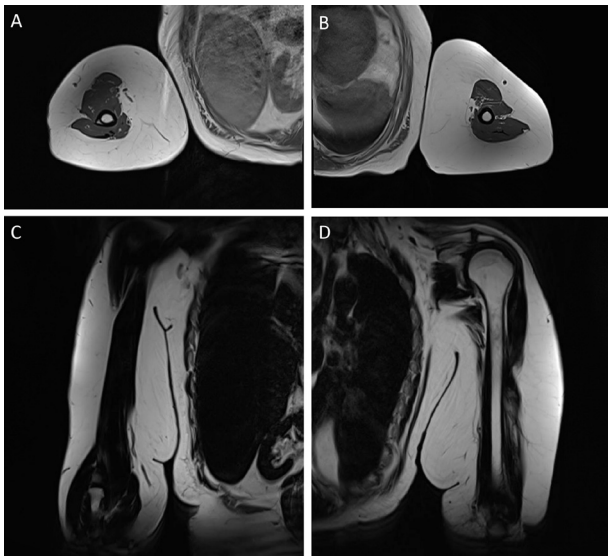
MRI of the patient's arms showing the accumulation of adipose tissue circumferentially. A. Right arm, frontal view. B. Left arm, frontal view. C. Right arm, transverse view. D. Left arm, transverse view.
